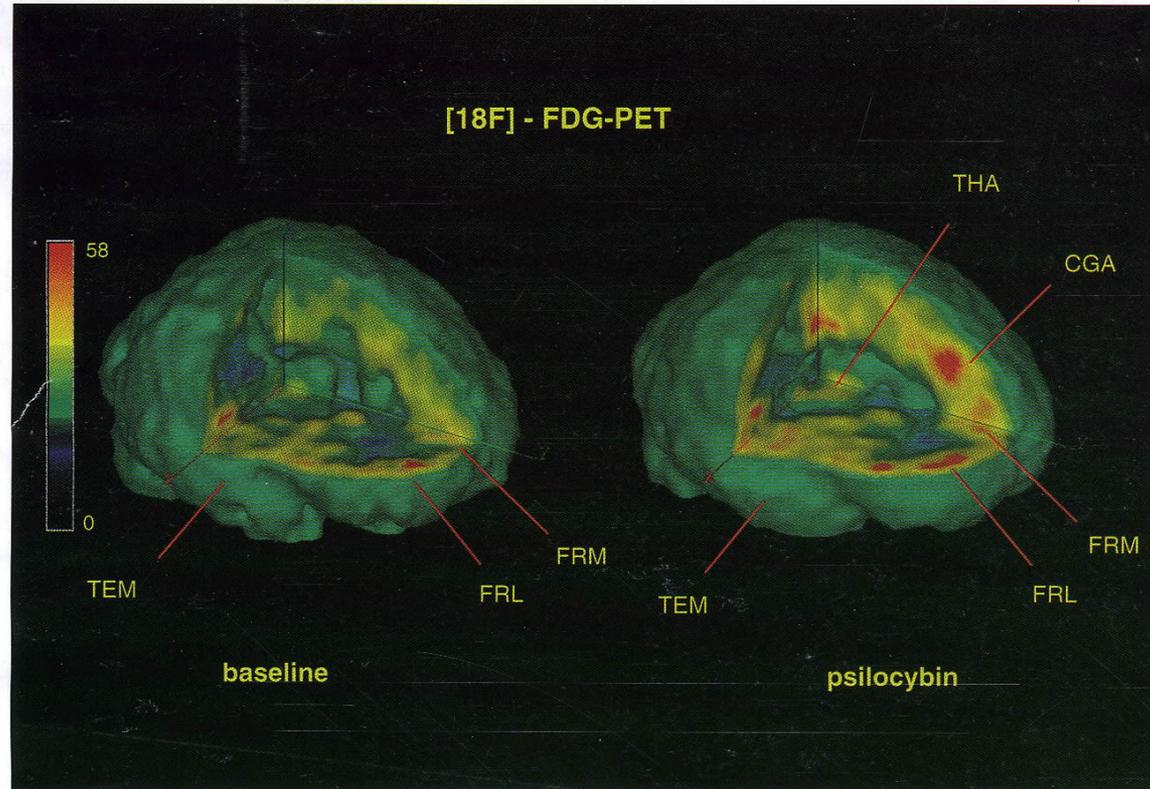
Two [18F]-FDG-PET images of the same subject under baseline (*left*) and psilocybin (*right*) conditions. Psilocybin administration (15–20 mg PO) resulted in a global increase of absolute cerebral metabolic rates of glucose (CMRglu: $\mu\text{mol}/100 \text{ mg}/\text{min}$) with most marked increases in the frontomedial (FRM), frontolateral (FRL), cingulate anterior (CGA), and temporomedial cortices (TEM). Subcortical structures such as the caudate nucleus, putamen, and thalamus were less stimulated than cortical regions. No significant changes were observed in either temporal pole. Red > orange > yellow > green = lowest value of CMRglu; note that the surface of the brain is not color-coded.
